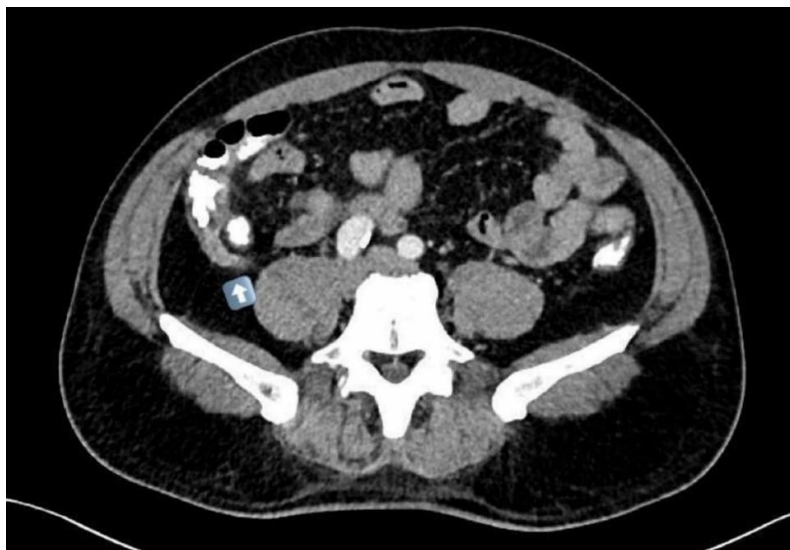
CT scan of the abdomen. Blue arrow is pointing to inflamed and thickened appendix
